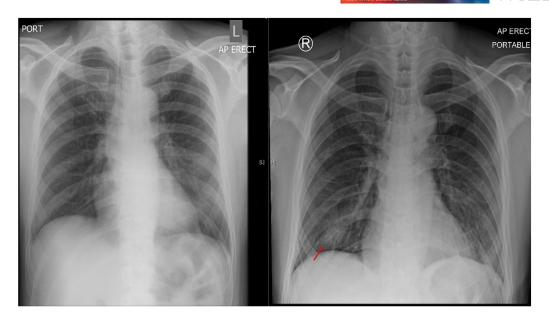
Chest radiograph on the left was performed on admission. Chest radiograph on the right was repeated on day 2 of admission when the patient turned hypoxic. Arrow highlighting new infiltrates from COVID-19 pneumonia
